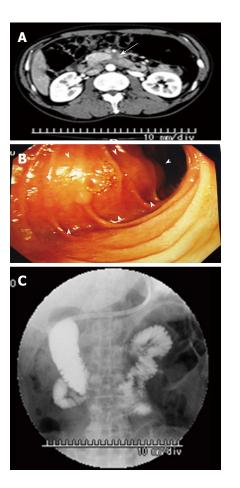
Contrast-enhanced computed tomography, duodenofiberoscopy, and hypotonic duodenography. A: Abdominal CT scan shows a poorly enhanced mass around the third portion of the duodenum (arrow); B: Duodenofiberoscopic findings reveal submucosal tumors at the third portion of the duodenum (arrowheads); C: Hypotonic duodenography reveals stenosis at the third portion of the duodenum. CT: Computed tomography.
